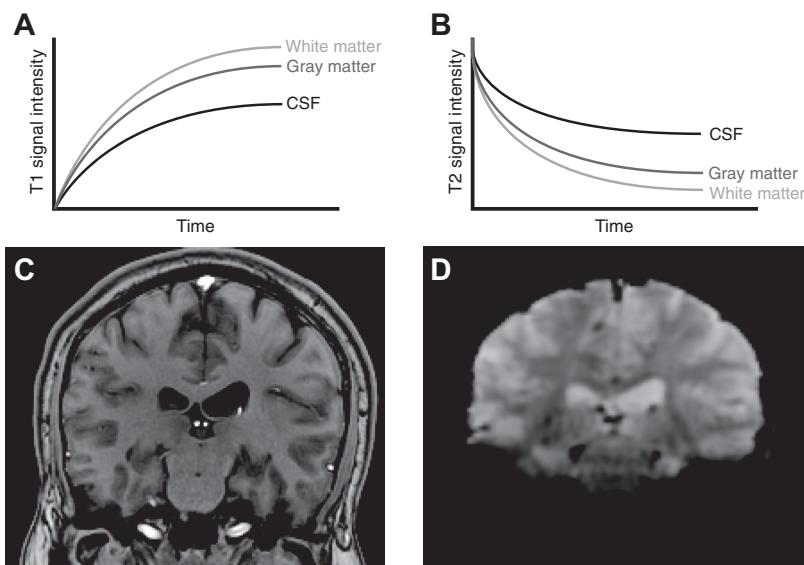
Different substances exhibit different T1 and T2 time constants. (A) For any given longitudinal magnetization relaxation time (T1), the white matter signal intensity will be greater than that of CSF. (B) In contrast, for any given transversal magnetization relaxation time (T2), the CSF signal intensity is greater than that for white matter. (C) Therefore, white matter will be bright and CSF dark on a T1-weighted image, while (D) white matter will be dark and CSF bright on a T2-weighted image. (C), (D) Courtesy of Dr. Rory Sayres.
